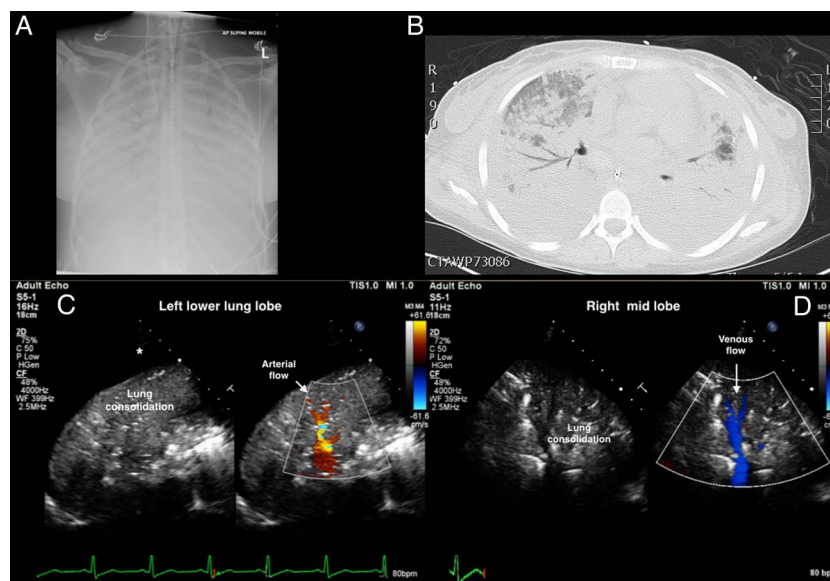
(A) Chest X-ray showing bilateral consolidation and air bronchogram, confirmed at CT scan (B). (C) Lung ultrasound transversal scan of the left lower lobe using the cardiac probe. Left side of the panel complete consolidation of inferior lobe (tissue-like pattern) surrounded by a small amount of pleural effusion (*). On the right side, colour flow Doppler technique is applied showing the arterial flow into the lung parenchyma (arrow—red flow). (D) The same technique applied to the right middle lobe and the venous flow is shown (arrow—blue flow).
